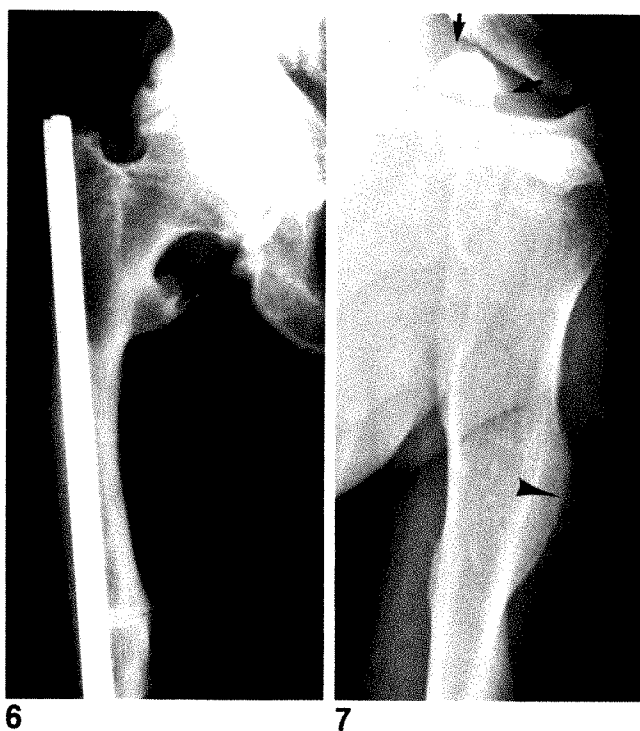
Radiograph shows marked bone proliferation involving supra-acetabular cortex and lesser trochanter and Looser zone in mid femur medially.
